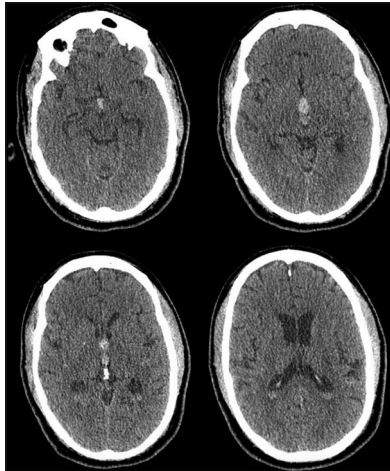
Case #2. Presenting axial non-contrast CT scan showing primary 3rd ventricular IVH
